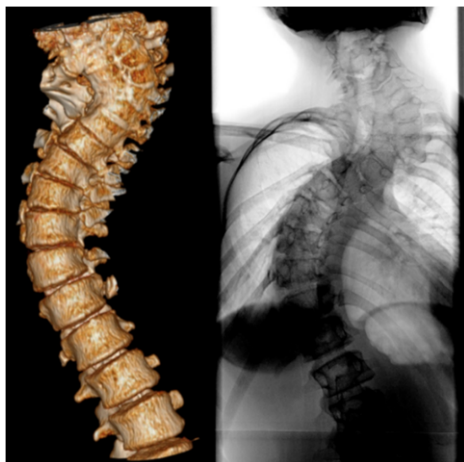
A reconstructed 3D image based on the CT-scan and an anterior-posterior radiograph of an included patient with congenital spinal anomalies (C2 – T6). The thoracic compensatory curve (T7 – L1, apex: disc T10/11, Cobb angle: 61°) with no congenital spinal anomalies, is the part of the spine that is analyzed in this study.
